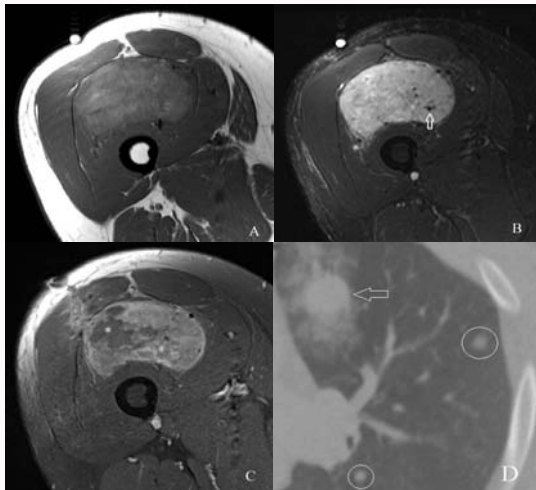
32 year old with a right thigh mass and multiple pulmonary nodules. A – C: Axial (A) T1-weighted TSE, (B) fat-suppressed T2-weighted TSE, and (C) gadolinium-enhanced fat-suppressed T1-weighted magnetic resonance imaging of the right thigh demonstrates an anterior compartmental soft tissue mass with increased T1-weighted signal relative to skeletal muscle, hyperintense T2-weighted signal with several peripheral and internal flow voids (arrow in B), and moderate intravenous contrast enhancement with an area of necrosis (* in C). D: Axial CT image of the left lung demonstrates a dominant solid lung nodule (arrow) with surrounding ground glass opacities and other small rounded solid pulmonary nodules (circles).
